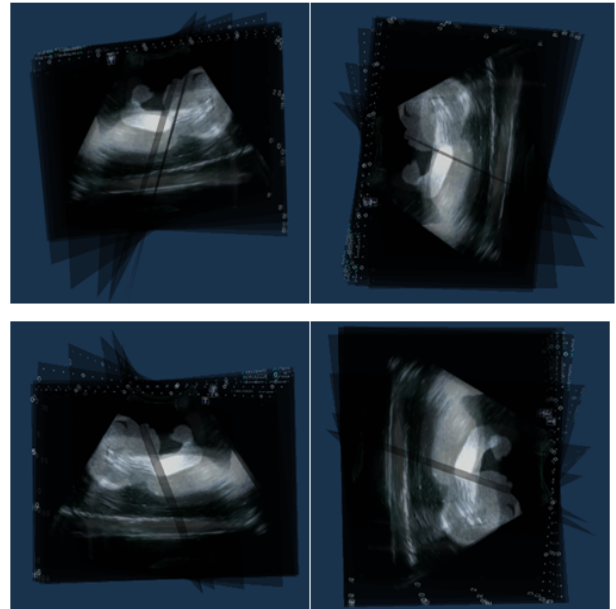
3D image reconstructed view from 15 multi-orientation ultrasound images
